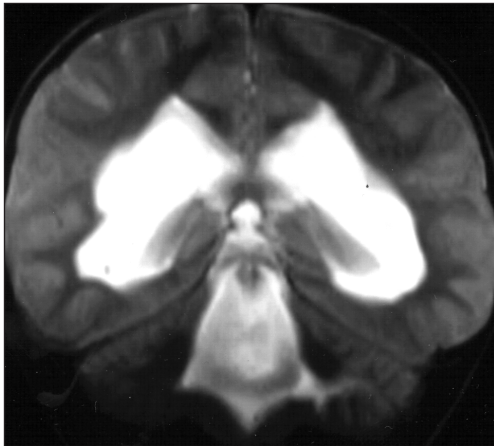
Coronal T2-weighted magnetic resonance image shows hydrocephaly and dilatation in the 4th ventricle.
